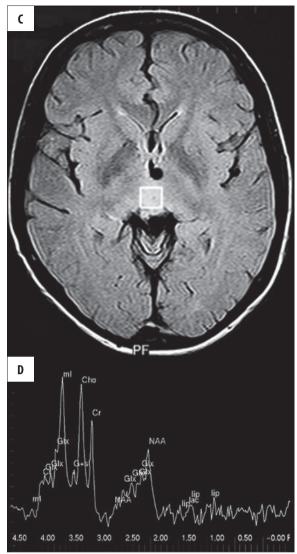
35-year-old women with tectal glioma (astrocytoma), confirmed by biopsy, revealed in MRI (see sagittal plane).
